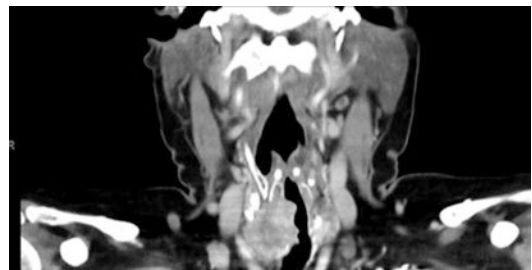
CT showing intraluminal invasion, coronal
